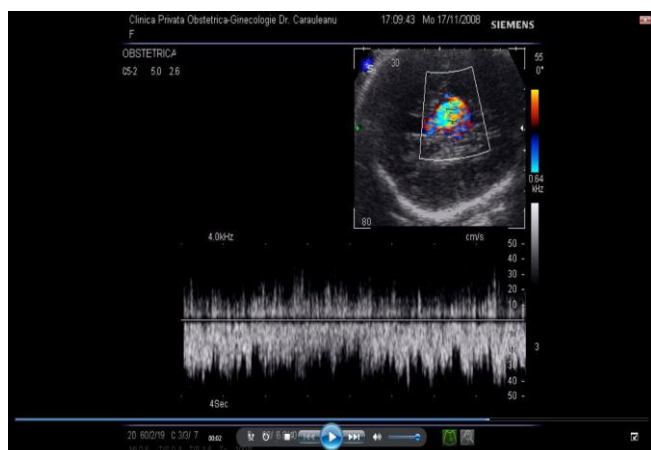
Pulsed Doppler image in the aneurysm.
